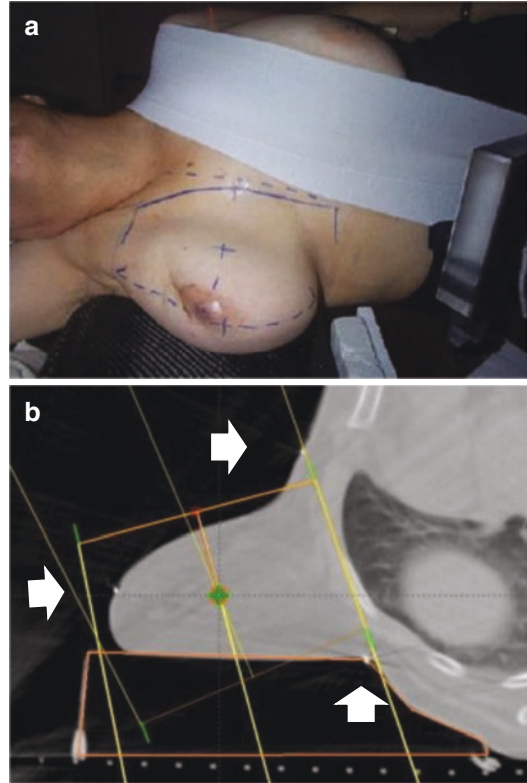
Patient positioned in a lateral decubitus and immobilisation device, including a strap holding the contralateral breast (A) the breast lies on the flat part of the breast board. The edge of the angled side is marked by a metallic wire which is visible on CT scan (arrows). Taken with permission from Kirova et al. [11]
